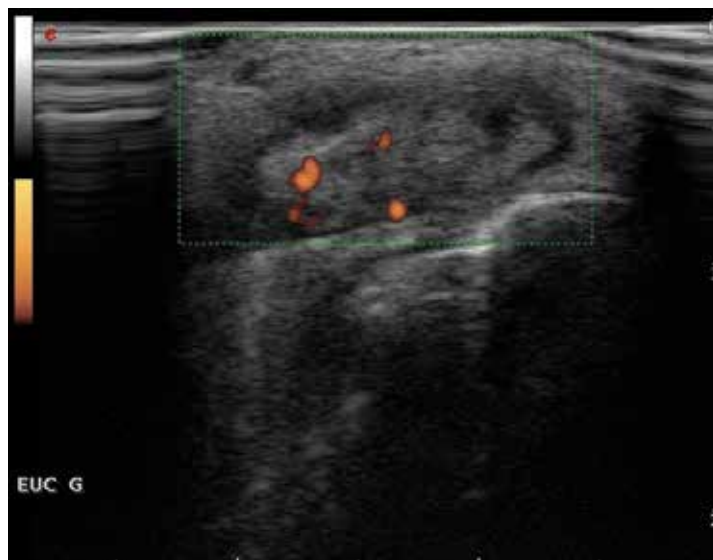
Tenosynovitis of the left extensor carpi ulnaris tendon with power Doppler signal
